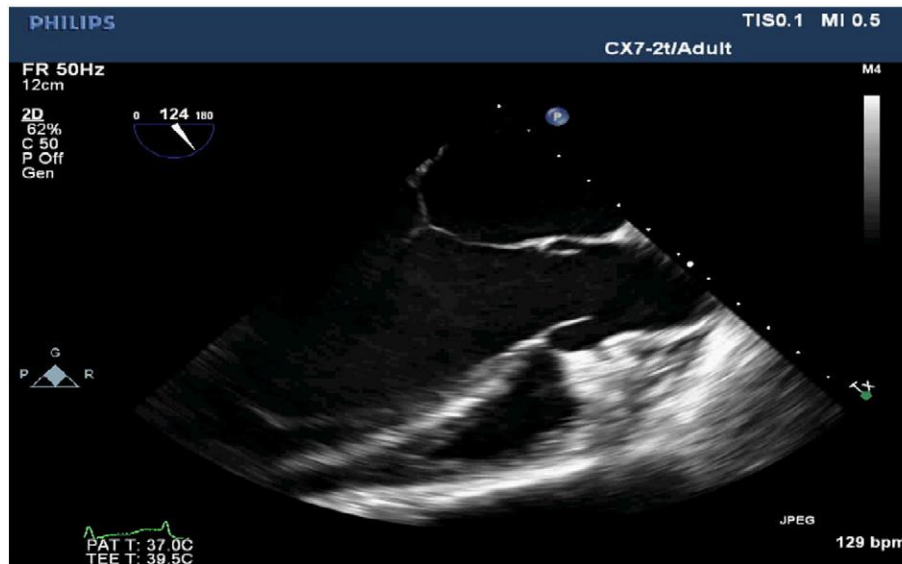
Transesophageal echocardiography of the patient.
